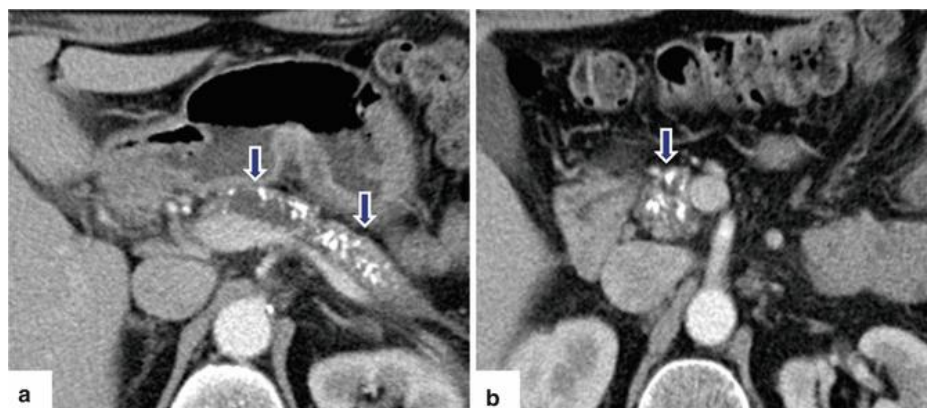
Chronic pancreatitis on CT: A 57-year-old male with alcohol abuse. CECT axial images (a, b) show a dilated pancreatic duct, multiple calcifications (arrows) throughout the pancreas, and parenchymal atrophy [31]
